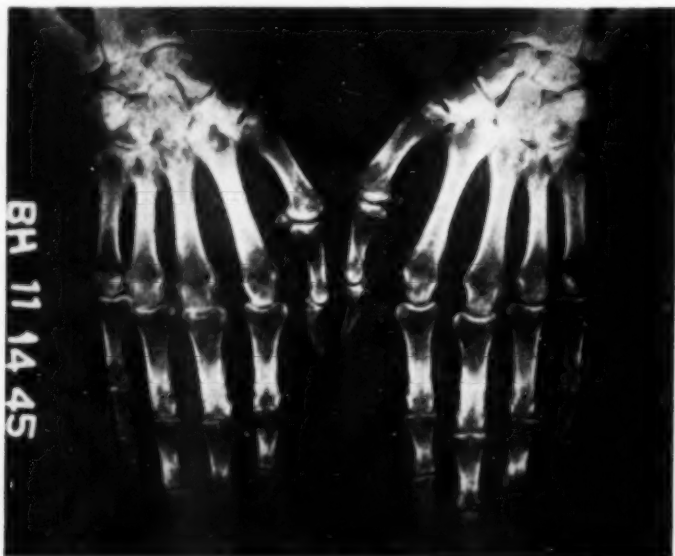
(Case 3) Possible polyarteritis nodosa. X-rays of the hands showing osteoporosis, more marked at the articular ends of the bones, and narrowing of the proximal interphalangeal joints. Findings indistinguishable from those occurring in rheumatoid arthritis.
